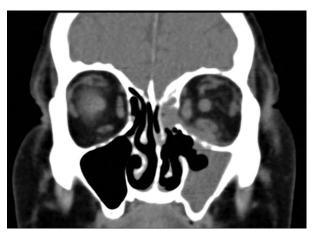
Coronal CT scan demonstrating left inferior orbital abscess.
